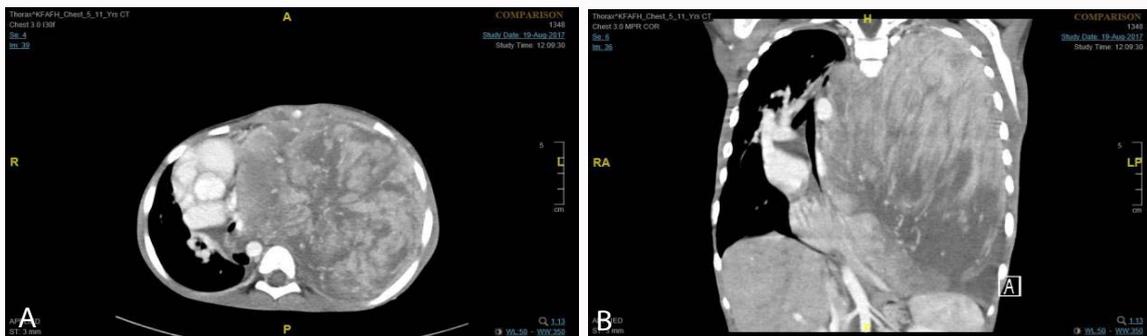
& 2B: CT scan, axial & coronal showing a large heterogeneous necrotic soft tissue mass occupying the whole left hemithorax. The lesion is encroaching into the middle and upper mediastinum and is inseparable from the mediastinal structures. Mild mass effect is seen over the left main bronchus. The left lung lower lobe shows some aeration and atelectasis. No evidence of pulmonary infiltration. The left second rib shows destructive expansion due to tumor infiltration. Noted is mild left side pleural effusion.
